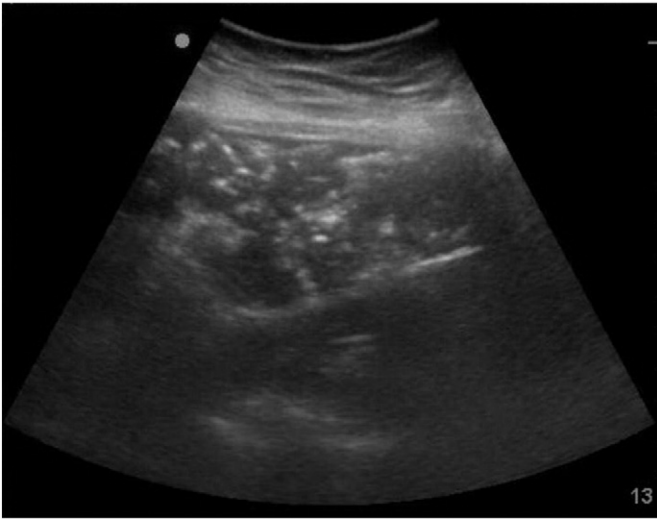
Right upper quadrant bedside ultrasonography.
